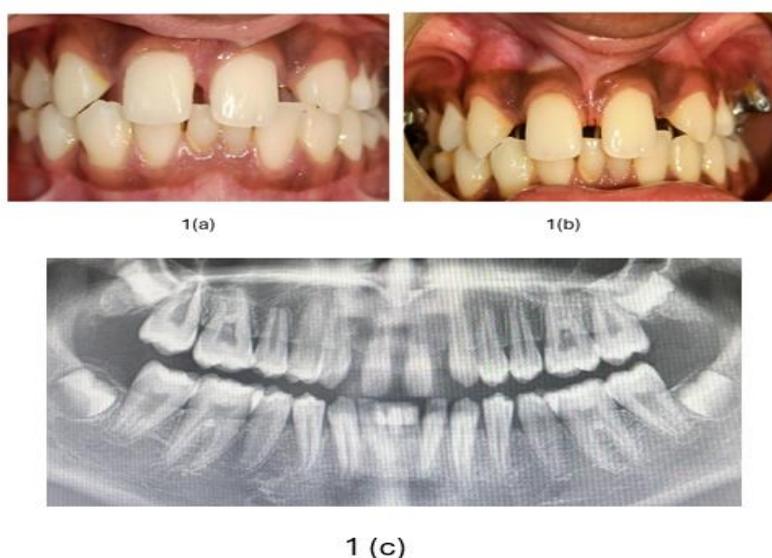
(a) Spacing between the maxillary anterior teeth. (b) High-attached maxillary labial frenum.(c) Orthopantomogram showing congenitally missing maxillary right and left lateral incisors.
